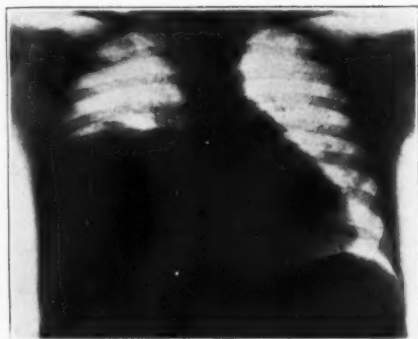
Roentgenogram taken three days after operation.
